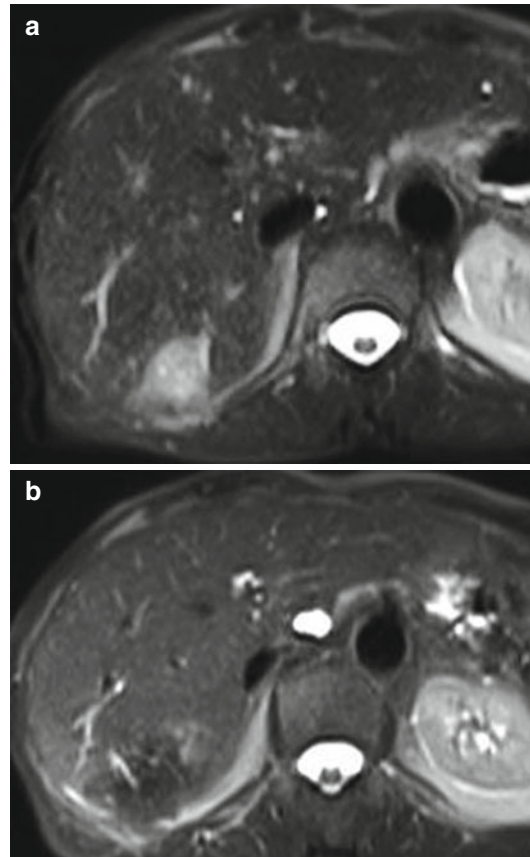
T2-weighted MR-imaging using fat-suppressed HASTE-Sequence demonstrates clearly a hyperintense metastatic nodule in segment 6 of the liver (a). Follow-up imaging 6 months after percutaneous RF ablation revealed no evidence of residual tumor (b)
